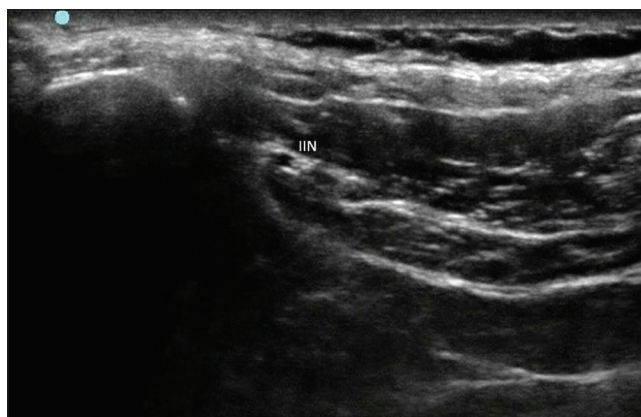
Ultrasonographic image show the ilioinguinal nerve between the internal oblique and transversus abdominis muscles
